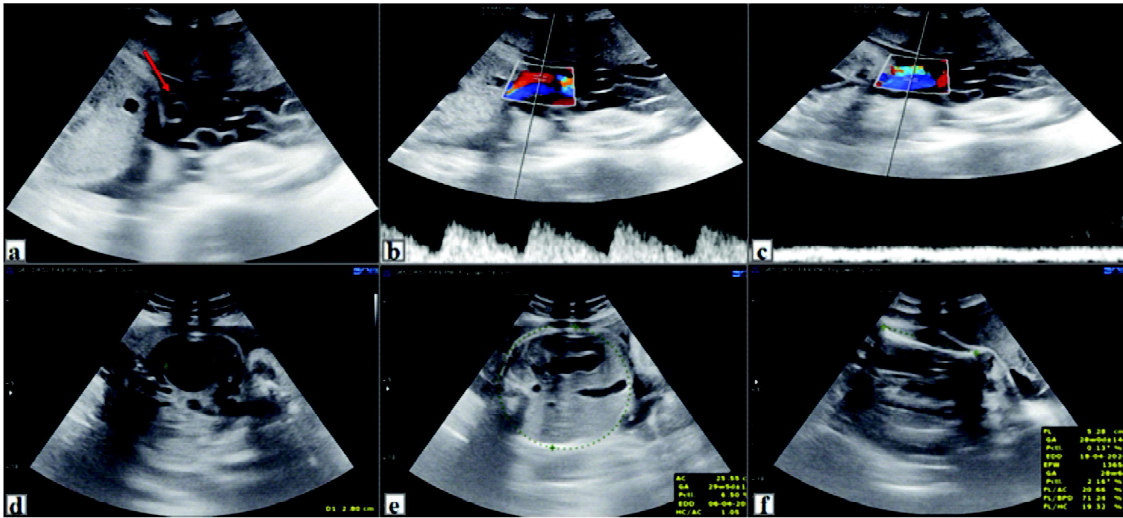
This was a patient for antenatal ultrasound, 33 years, G4P4A2 at 31 weeks 4 days. 2D gray scale ultrasound image showing a) single umbilical artery (indicated by red arrow), b), c) Doppler images showing corresponding waveforms of the umbilical artery and umbilical vein, d) associated renal pyelectasis e) AC was < 10th percentile, f) FL was < 3rd percentile and EFW was < 3rd percentile, suggestive of FGR. Risk assessment and non-invasive screening for aneuploidy was done, which turned out to be negative. The patient was advised follow up with Doppler.
